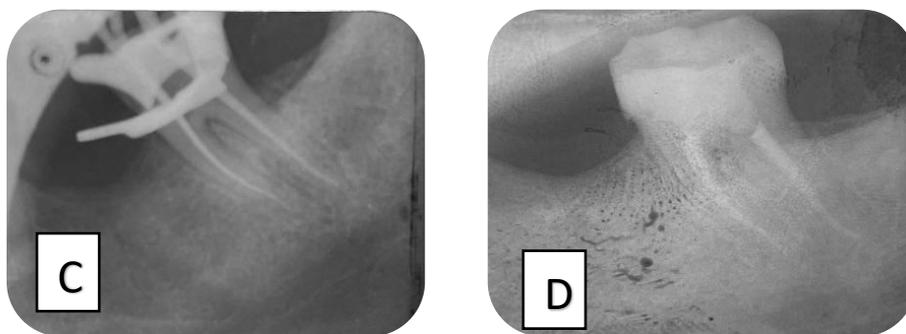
cone fit in place (C), Post-operative radiograph after coronal obturation (D).
